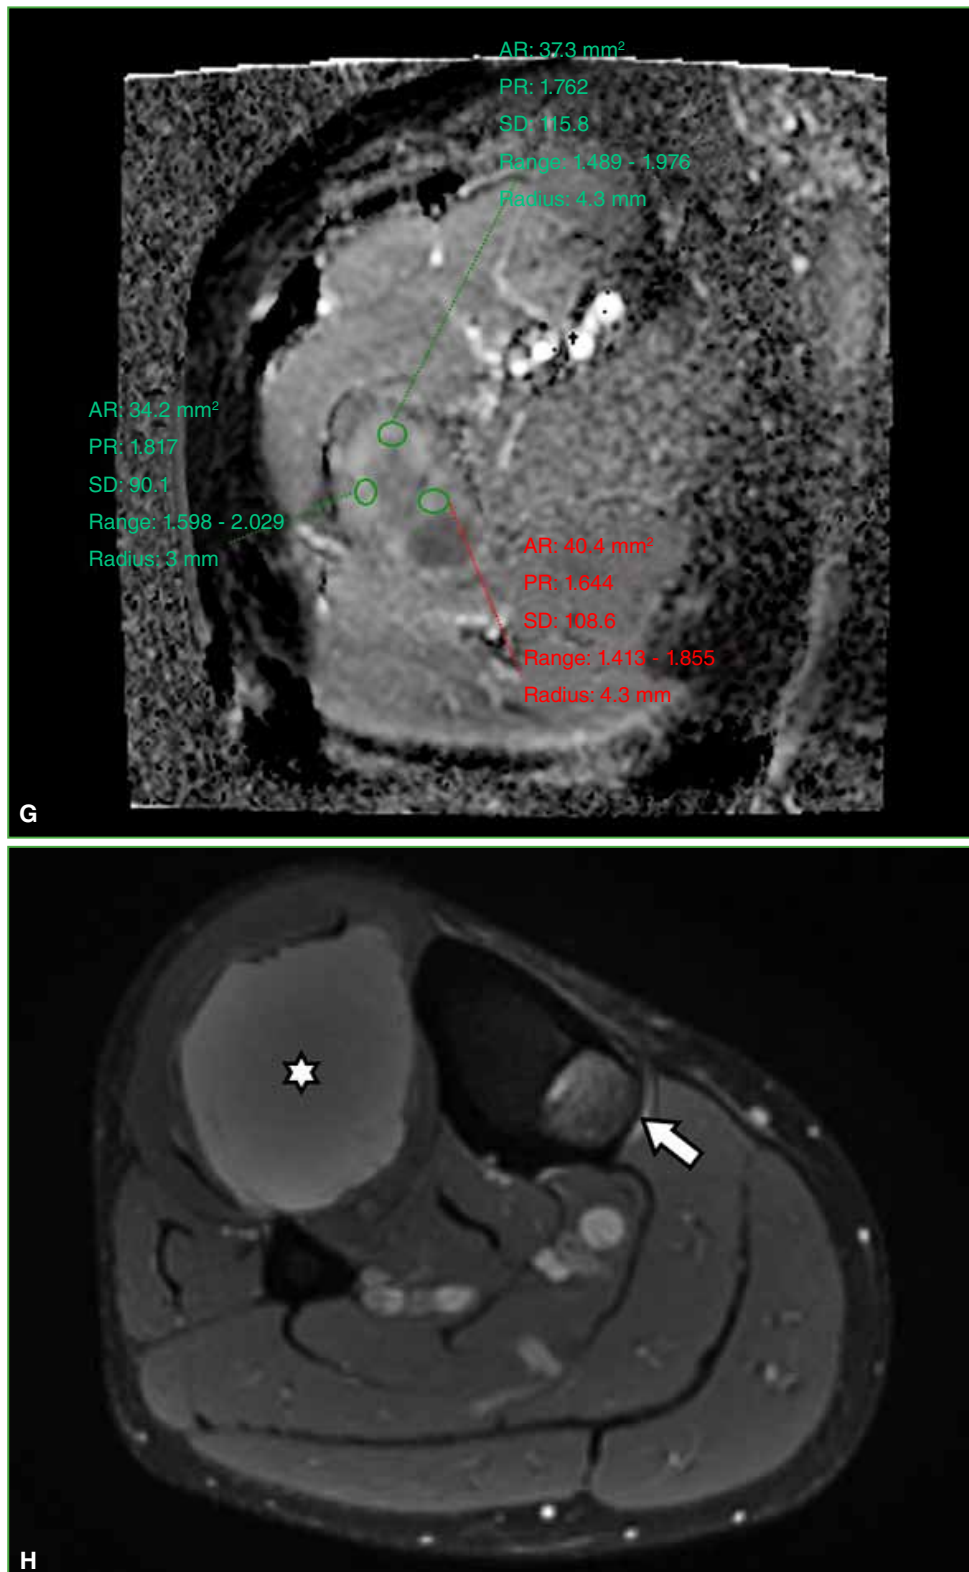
G. Map of the apparent diffusion coefficient with an average value of $1.7 \times 10^{-3} \text{ mm}^2/\text{s}$, marking a facilitated diffusion. H. Right leg MRI, axial plane, STIR sequence. Hyperintense lesion in the proximal tibia (arrow) and markedly hyperintense lesion in soft tissue, in the anteroexternal muscle plane (asterisk).
